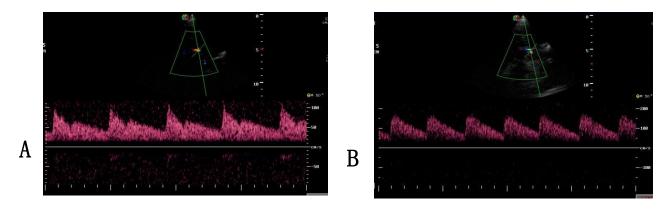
(A) Transcranial Doppler US image showed normal MBFV of 66 cm/s in the right MCA immediately after aneurysm rupture. (C) Follow-up transcranial duplex Doppler US image obtained after 10 days showed an increased MBFV of 116 cm/s in the right MCA. The MFV is normal (66 cm/s) but has also increased since baseline (66 cm/s).
